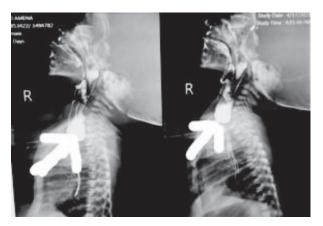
Upper GIT contrast x-ray showing proximal dilatation of the oesophagus
